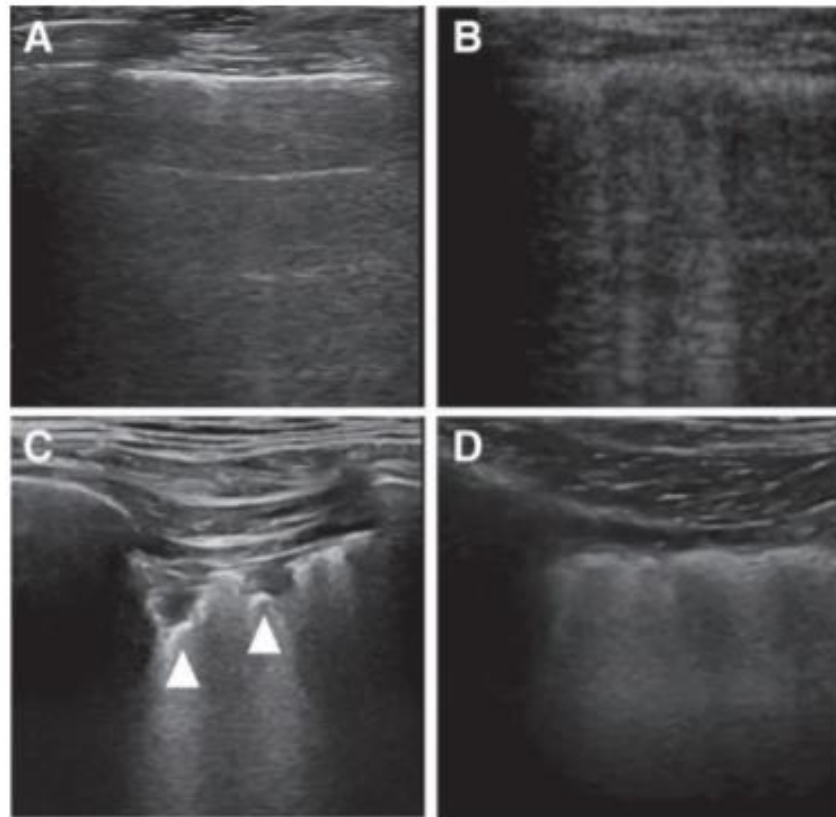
Lung sonographic signs associated with atelectasis. (A) Score 0: normal lung. Pleura is thin and A-lines are apparent. One or two well-spaced lines per intercostal space are allowed. (B) Score 1: more than three well-spaced vertical lines per intercostal space (B-lines). (C) Score 1: juxtapleural consolidation (*arrows*) with normal pleural line. Juxtapleural consolidation is caused by a loss of lung aeration. It commonly arises from the pleural line. (D) Score 2: loss of A-line with multiple juxtapleural consolidations and irregular pleural lines are seen. Score 3 (loss of lung sliding and appearance of lung pulse; Supplemental Digital Content 1, <http://links.lww.com/ALN/C690>) and score 4 (large consolidation, no occurrence in our study) are not presented here.
